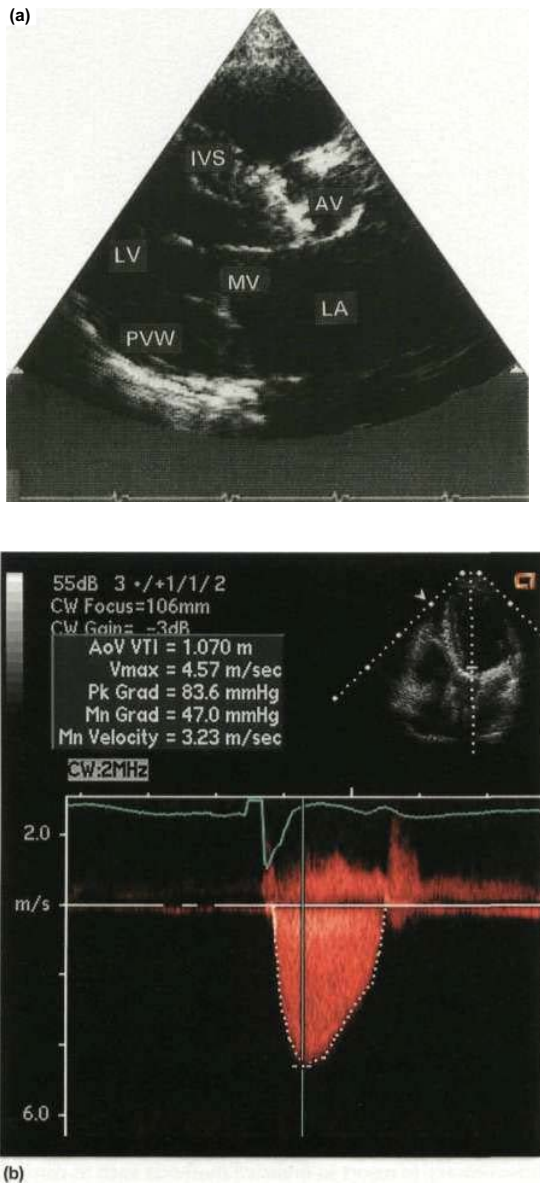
(a) Two-dimensional echocardiogram (long-axis view) in a patient with calcific aortic stenosis. The calcium in the valve generates abnormally intense echoes. There is some evidence of the associated left ventricular hypertrophy. (b) Continuous-wave (CW) Doppler signals obtained from the right upper parasternal edge, where the high-velocity jet from the stenotic valve is coming towards the transducer. AV, aortic valve; LA, left atrium; MV, mitral valve; LV, left ventricle; IVS, interventricular septum; PVW, posterior ventricular wall.
